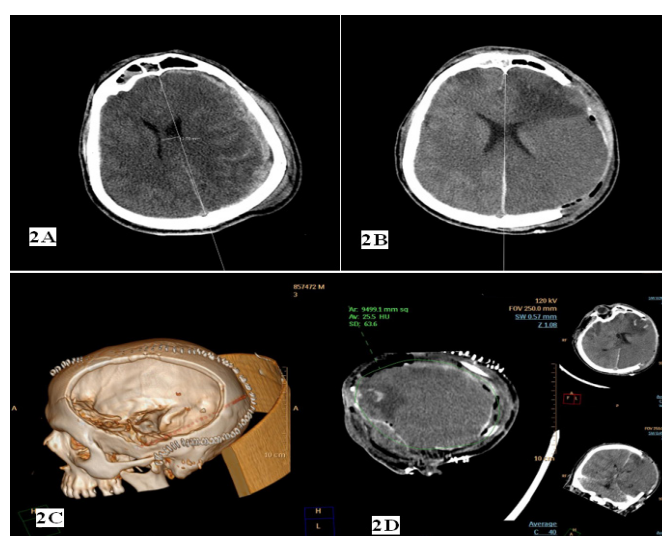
Photographs show the preoperative (2A) and postoperative (2B, 2C) cranial CT images of a patient with traumatic acute subdural hematoma. Photographs also show the measurement technique of the craniectomy area in sagittal, coronal, and axial CT images of this patient (2D)
